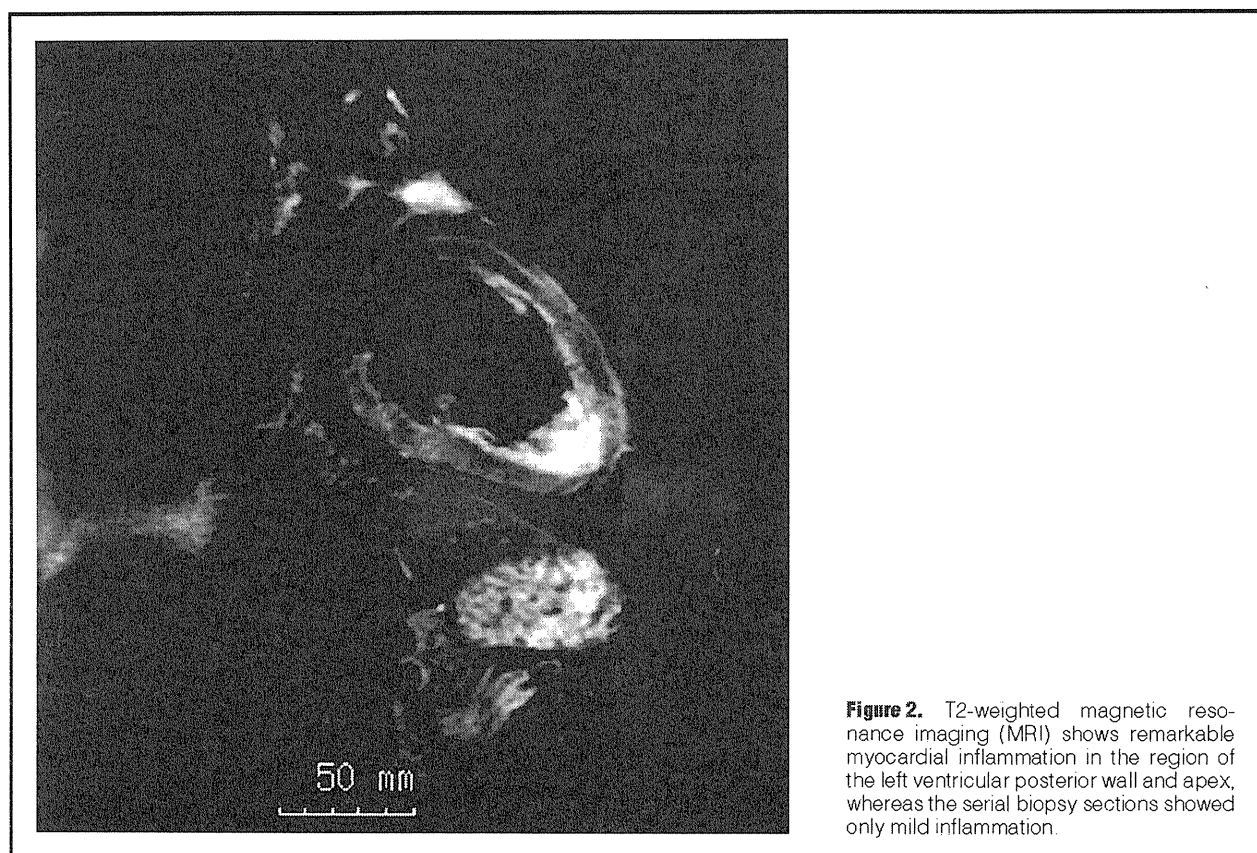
T2-weighted magnetic resonance imaging (MRI) shows remarkable myocardial inflammation in the region of the left ventricular posterior wall and apex, whereas the serial biopsy sections showed only mild inflammation.
